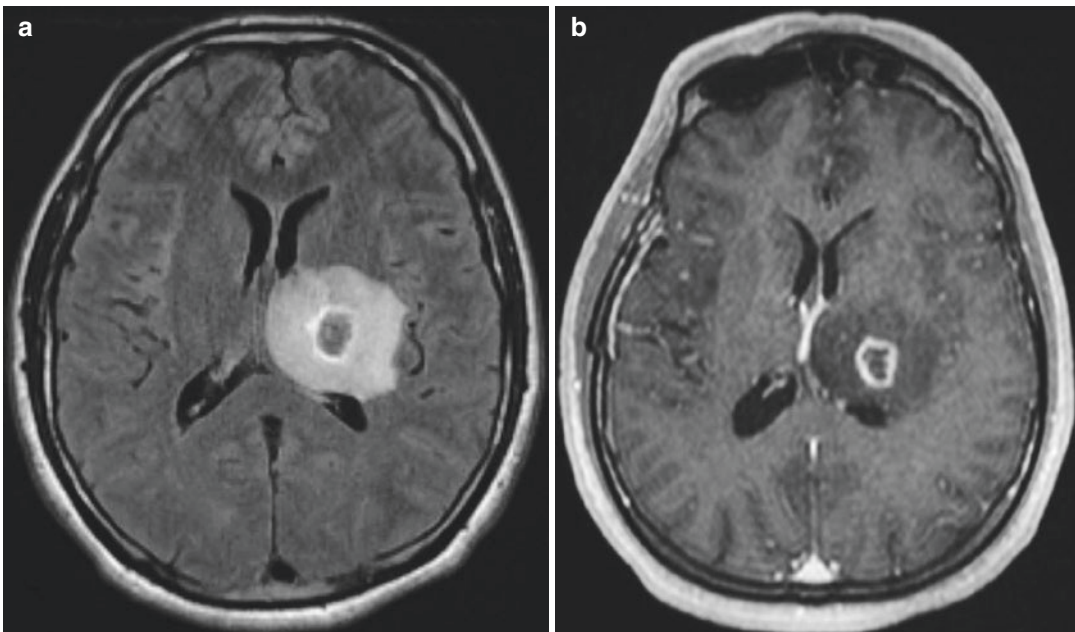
Axial FLAIR brain MR (a) and axial post-contrast T1-weighted brain MR (b) in a 34-year-old male with AIDS demonstrates ring-enhancing lesions with surrounding edema consistent with toxoplasmosis brain abscess
